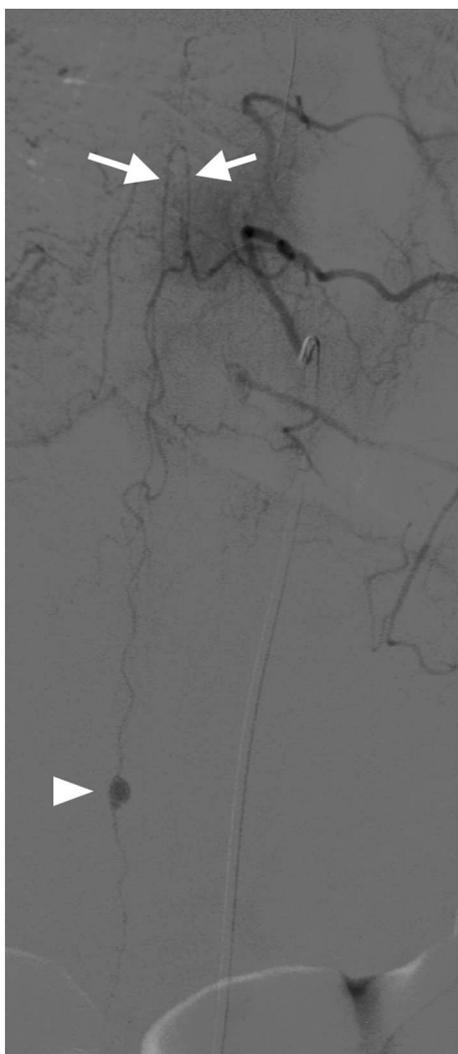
Frontal digital subtraction angiography revealed a 6×3.5 mm pseudoaneurysm (arrowhead) at the level of T11-T12 corresponding to the nodular lesion seen on MRI. The pseudoaneurysm arises from the distal/inferior segment of the anterior spinal artery which was supplied by the artery of Adamkiewicz originating from the T8 spinal artery. Subtle contour irregularities in the artery of Adamkiewicz and the proximal anterior spinal artery can also be seen (arrows).
